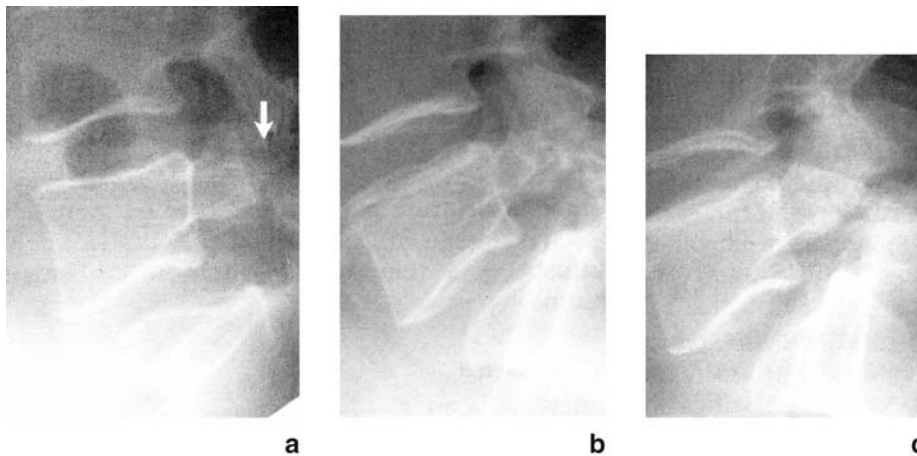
(a-c). Standard x-ray with morphodynamic tests (flexion-extension): First grade spondylolisthesis according to Meyerding with bilateral isthmic spondylolysis (a) standard view, (b) flexion, (c) extension
